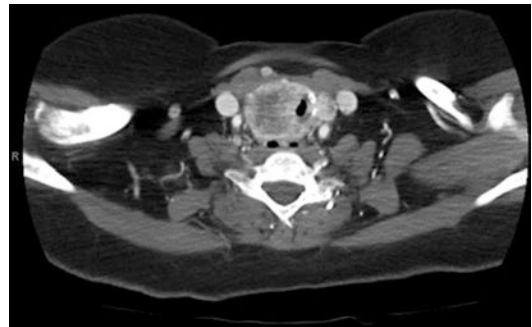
CT showing intraluminal invasion
